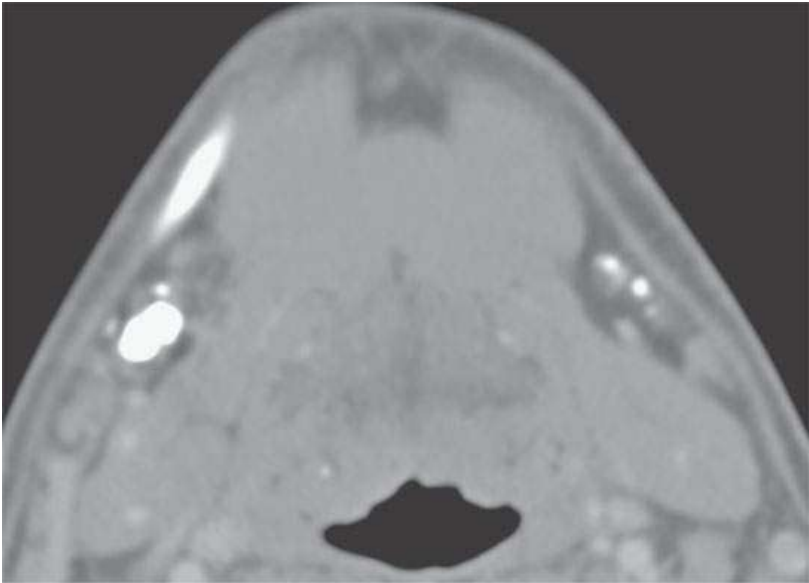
Computed tomography of calcified level 1 nodes of uncertain cause but nonneoplastic and probably inflammatory etiology.
